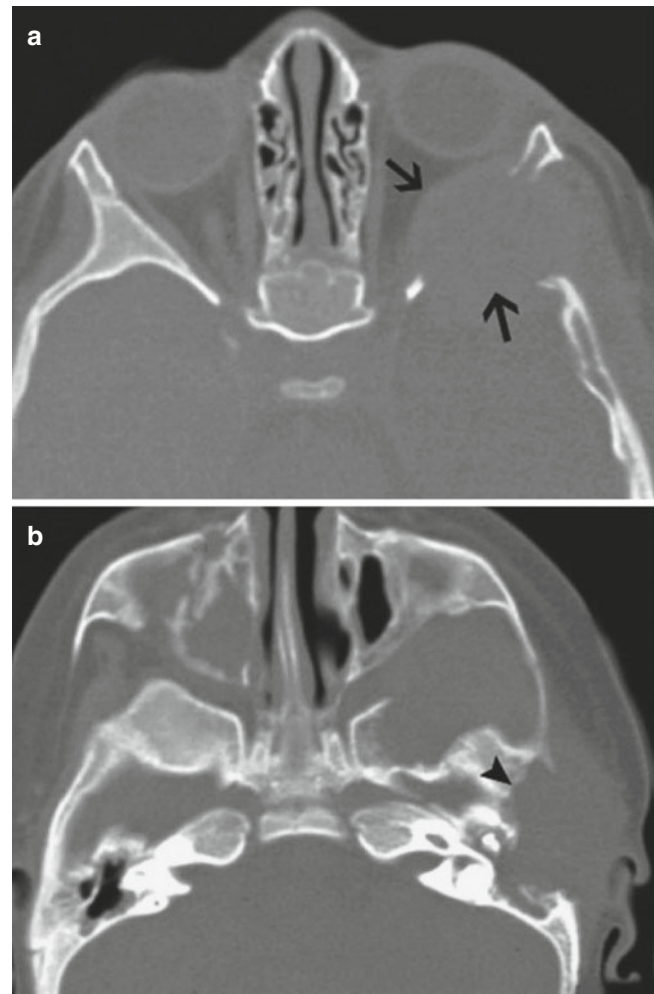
Langerhans cell histiocytosis (a) CT scan shows a lytic lesion of the frontal and sphenoid bones (arrows) (b) CT scan shows destruction of the temporal bone (arrowhead)
